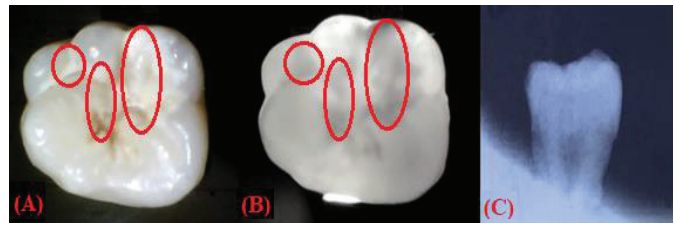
Sample 3 under visible light (A), NIR light (B), and X-rays (C).
